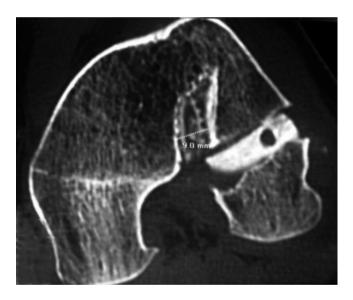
Axial CT cut of the distal femur of a left knee. The previous vertical femoral socket is seen as in the new femoral tunnel drilled with the "outside-in" technique
